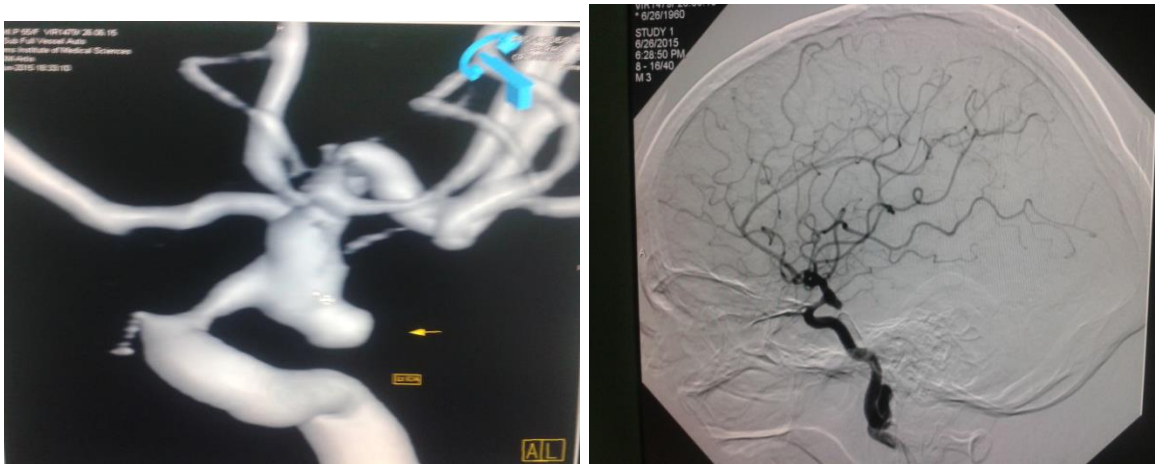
CT brain plain- SAH noted in bilateral sylvian fissures, DSA -S/O P com artery aneurysm- directed posteriorly, measuring 6.6x3.1x4.4 neck measuring 1.9mm. Treatment- Left pterional craniotomy plus clipping of aneurysm plus wrapping, Aneurysm ruptured during dissection. Temporary clip at proximal ICA for 3 minutes and patient recovered well.
